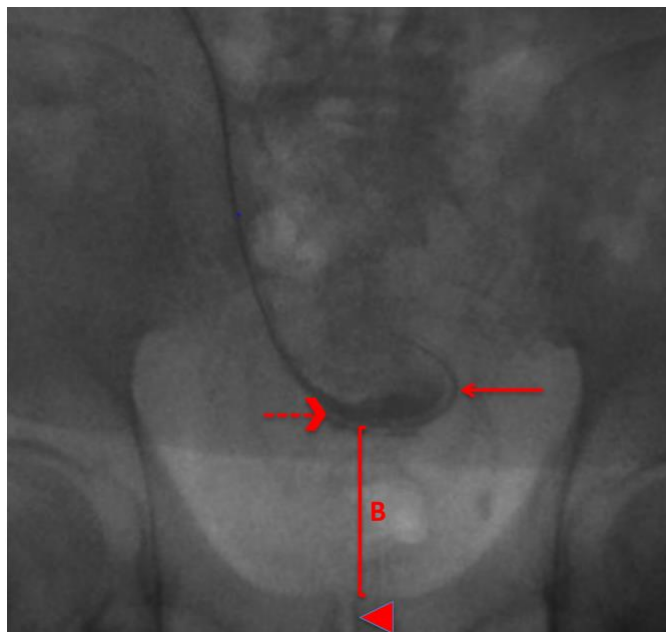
Fluoroscopic radiograph of staged peritoneal dialysis catheter insertion (Insertion of peritoneal segment of peritoneal dialysis catheter) with proposed radiographic measurement: B) Cranial border of the pubic symphysis to bottom of catheter tip – referencing midline, in a standard anterior-posterior pelvic view, with the patient in the supine position (solid arrow – catheter tip, dashed arrow – pooled radiocontrast withdrawn, arrowhead – pubic symphysis).
